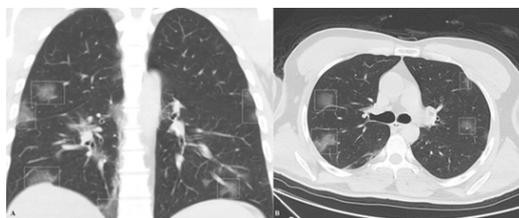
Coronal (A) and axial (B) CT images of a 39-year-old male patient shows bilateral peripheral multifocal GGOs (frames) which are compatible with the "typical appearance".
